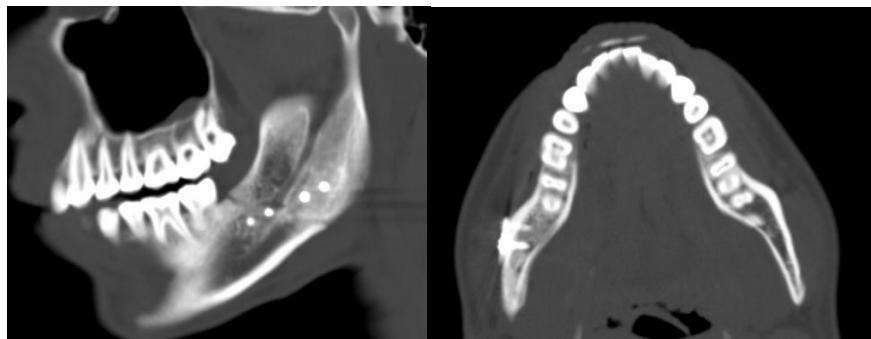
Postoperative CT-Scans in the sagittal and axial planes after plating
